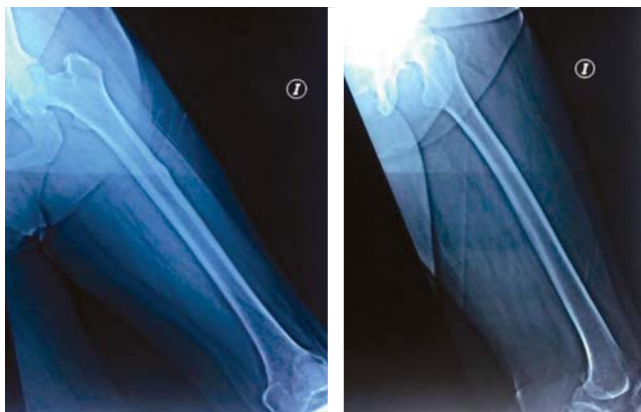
Anteroposterior and lateral radiograph of the left femur, showing incomplete atypical fracture with proximal lateral cortical thickening.
